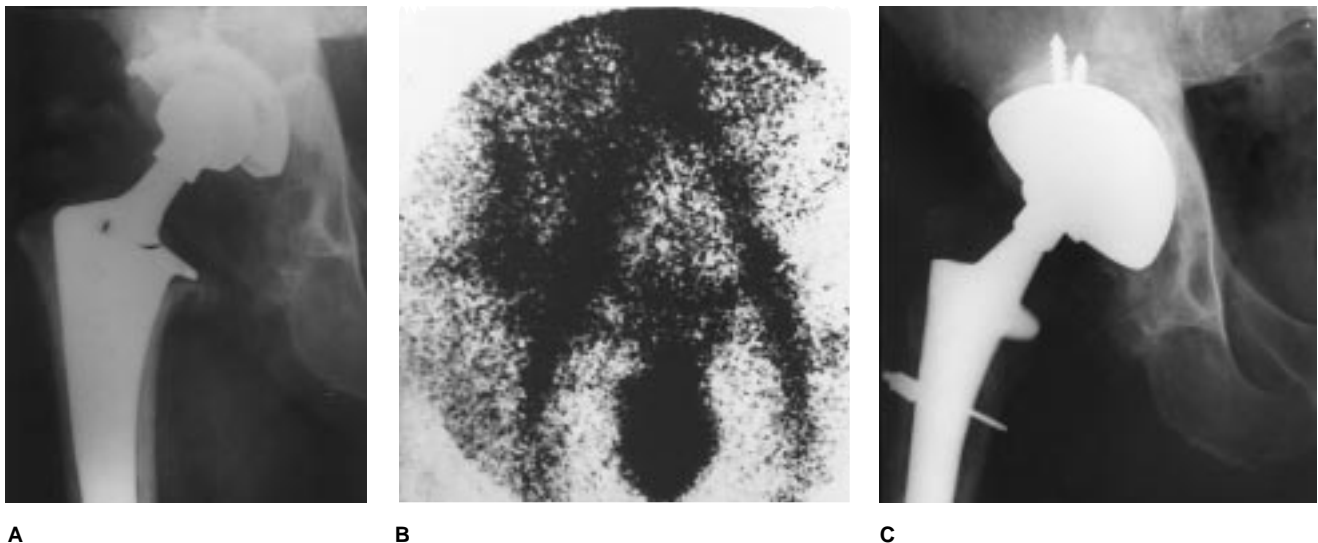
Images of a 60-year-old man with a painful revision total hip arthroplasty who experienced prolonged drainage (3 weeks) after the primary procedure. A, Anteroposterior radiograph reveals a cementless total hip arthroplasty 18 months after surgery. There are erosions of the lateral femoral cortex about the distal third of the femoral stem. The patient complained of groin and thigh pain predominantly with weight-bearing but also with rest and during the night. His ESR (Westergren) was 40 mm/hr. B, An image obtained with In-111-labeled IgG (polyclonal) reveals increased uptake about the proximal femur and acetabulum, consistent with low-grade sepsis. Two species of *Staphylococcus epidermidis* were isolated from a hip aspirate: one was β -lactamase-positive, glycocalyx-negative, and methicillin-susceptible; the other was β -lactamase-positive, glycocalyx-negative, and methicillin-resistant. C, Anteroposterior radiograph obtained 18 months after a two-stage reconstruction. Six months after Girdlestone resection arthroplasty, the hip was reconstructed with a cementless total hip arthroplasty with hydroxyapatite coating on the proximal third of a calcar-buildup femoral component. The patient has returned to normal activities without pain, and the prosthetic-cement interfaces appear stable without erosions or other evidence of an ongoing infectious process.
